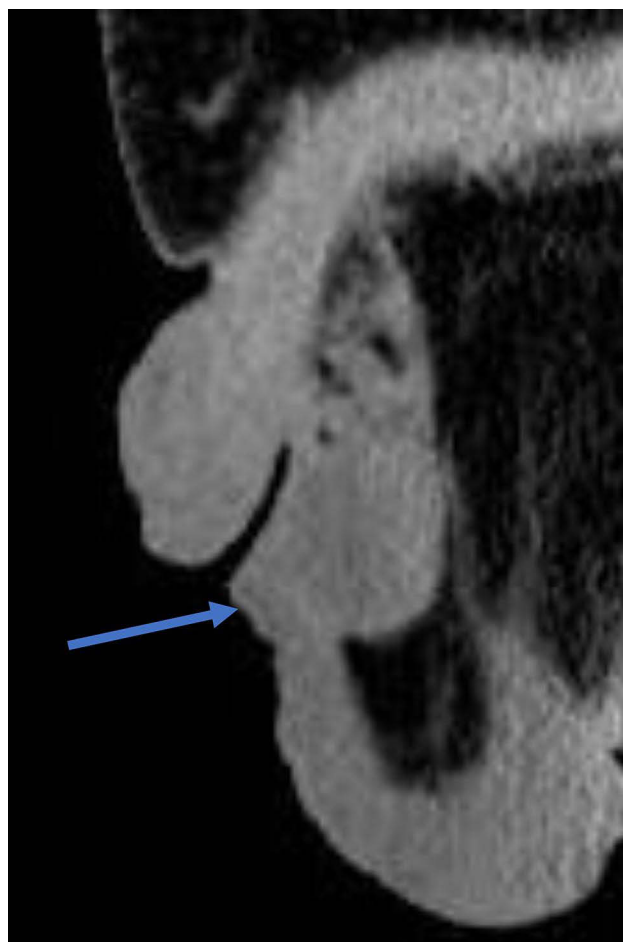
Computed tomography revealed an abscess with a diameter of 5 cm in the scrotum without gas image (sagittal section).
